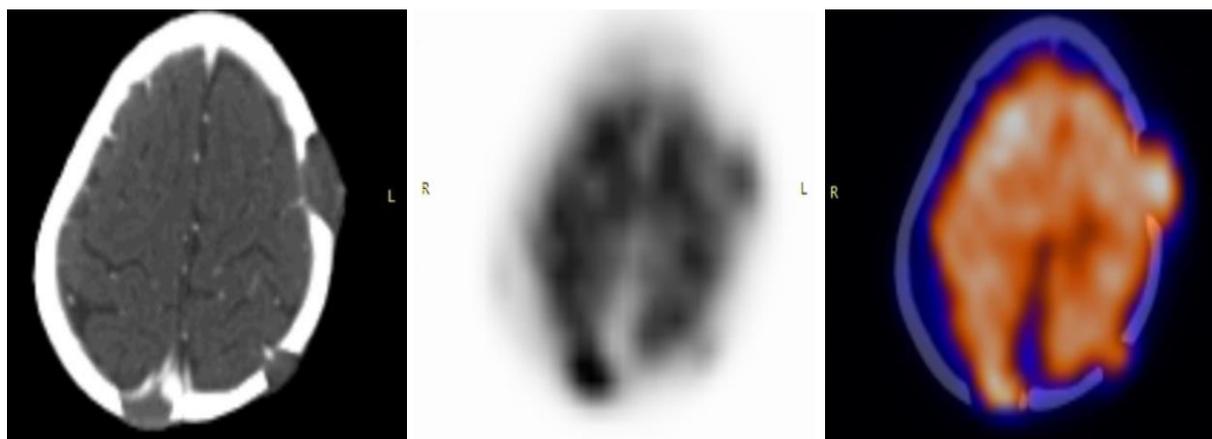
Axial CT-FDG PET and fused PET/CT of Skull shows FDG avid lytic bone lesions.
